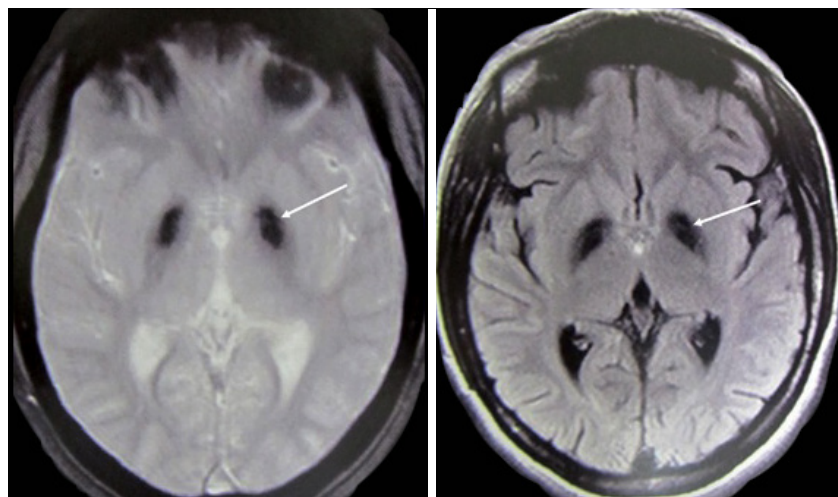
Patient with phospholipase A2 associated neurodegeneration (PLAN) due to *PLA2G6* mutations. Brain MRI shows marked hypointense signal with iron accumulation in globus pallidus.
